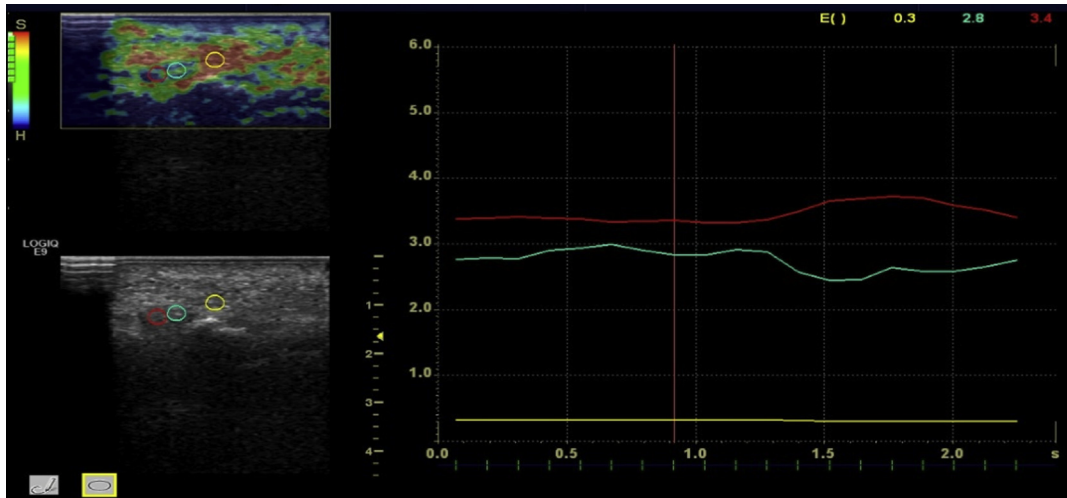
Coronal ultrasound image of the third intermetatarsal space of the left foot showing a solid hypoechoic lesion, consistent with Morton's neuroma, appearing heterogeneous but mostly green-blue on the color map, as seen in early-stage cases.
